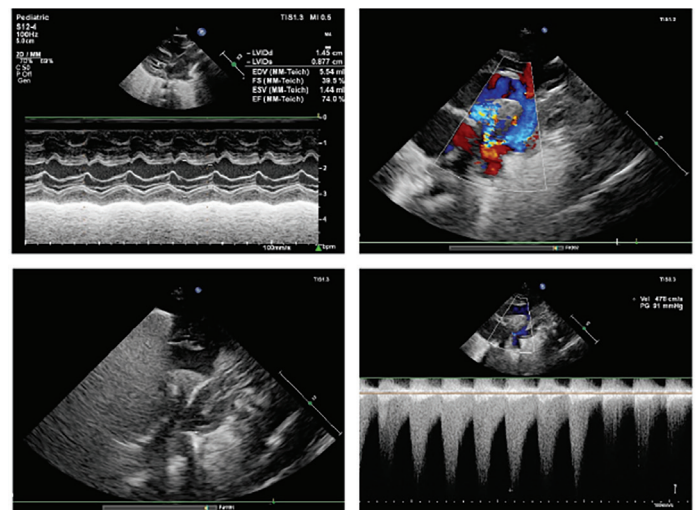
Echocardiography showed left ventricular dilatation and hypertrophy (upper left), severe narrowing of the distal transverse aorta and retrograde flow in the patent ductus arteriosus (upper right), severe coarctation of the aorta (2D image, lower left), and a very high-pressure gradient (95 mmHg from proximal to distal sites of the coarctation; lower right).
